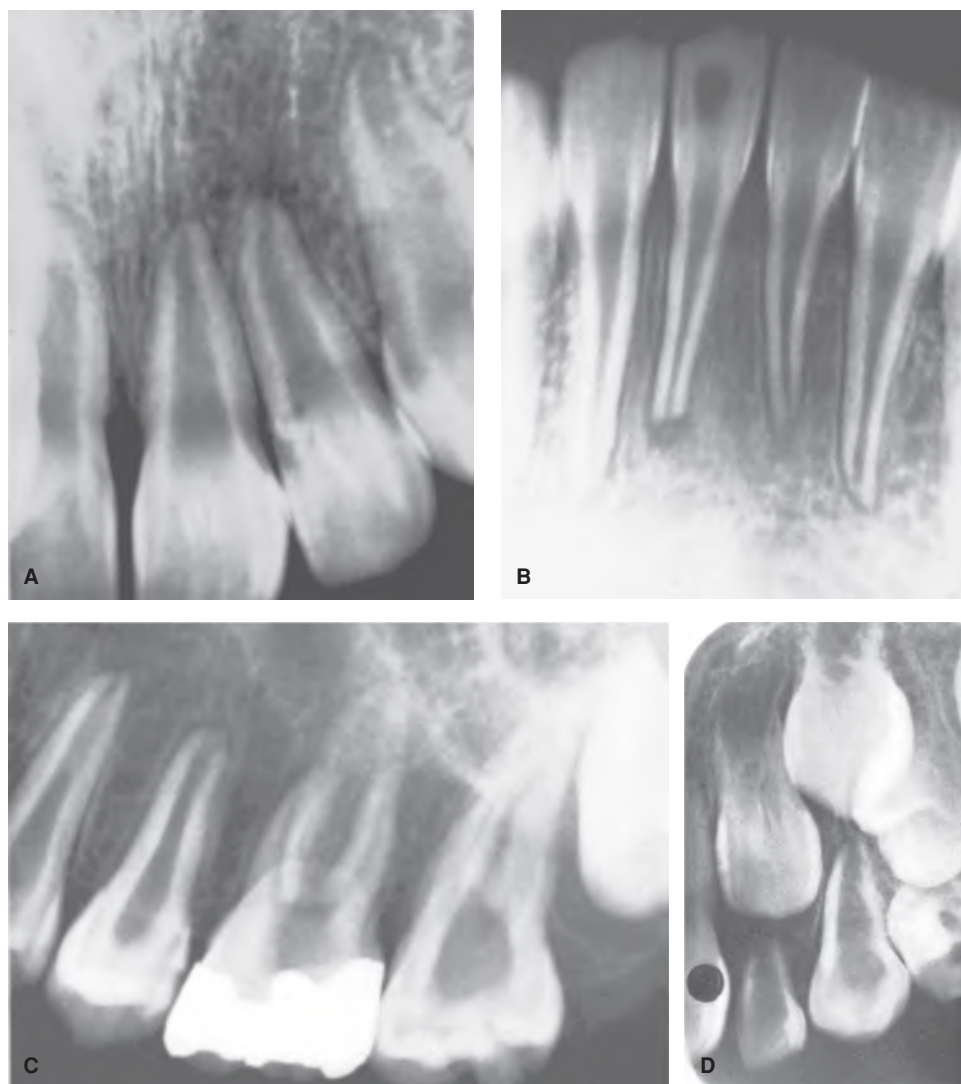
Unusual pulp dystrophy in *hereditary hypophosphatemia*. Incomplete calcification of dentin and large pulps leave these teeth vulnerable to infection and necrosis. A. Maxillary incisors at the age of 13. Note large pulp spaces. B. Mandibular incisors have been traumatized and pulp necrosis has developed. C. Large pulps can be seen in molar and premolar teeth. The pulp in the first molar later became necrotic. D. Large pulp size and shape are also apparent in the deciduous dentition. On the basis of these childhood radiographs, diagnosis can be made early about the patient's condition. Timely vitamin D therapy may prevent dwarfing.
